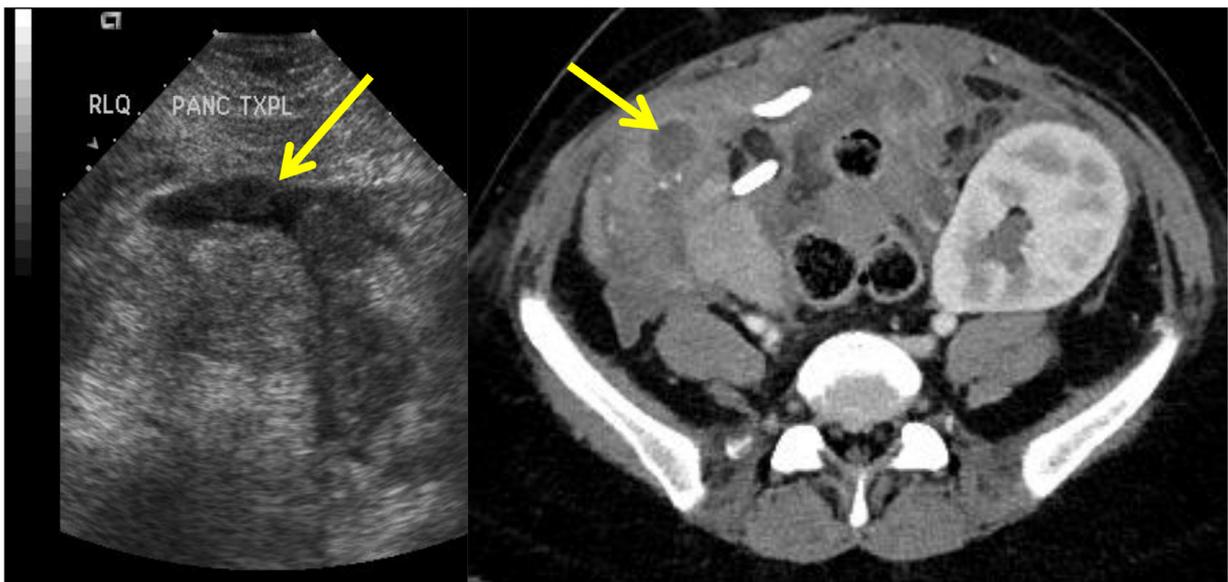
Post-operative fluid collections (arrow) may be characterized on either US (Image A) or CT (Image B). On US, the collection is a hypoechoic structure adjacent to the graft, while on CT it appears as a hypoattenuating fluid density structure near the pancreas. (Color version of figure is available online.)
